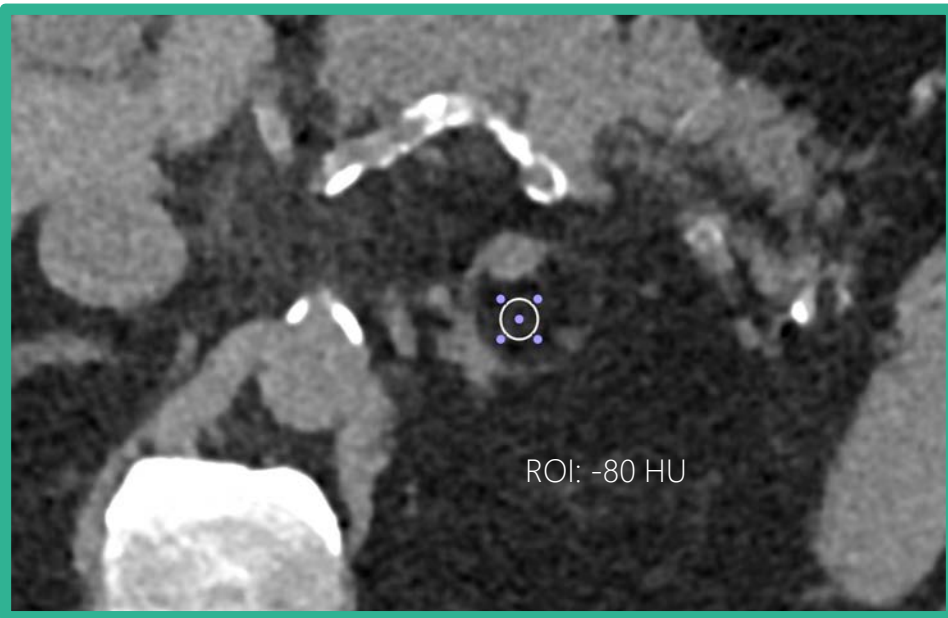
Axial abdominal unenhanced CT showing a tumour with macroscopic fat (Region of Interest attenuation measurement = -80 HU) suggesting a myelolipoma.
